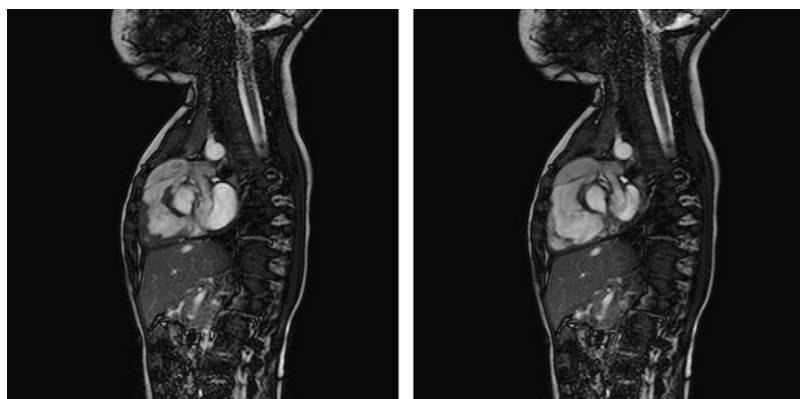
Magnetic resonance images in end systole and end diastole showing the bicuspid PTFE valve with little movement of the fold between the 2 halves of the leaflet throughout the cardiac cycle attesting to the stability of the valve shape. The distal placement of the valve free edge is apparent, just proximal to the branch pulmonary artery origins. This is an infant with repaired tetralogy of Fallot, and the oversizing of the valve is evident together with preserved ventricular function.
